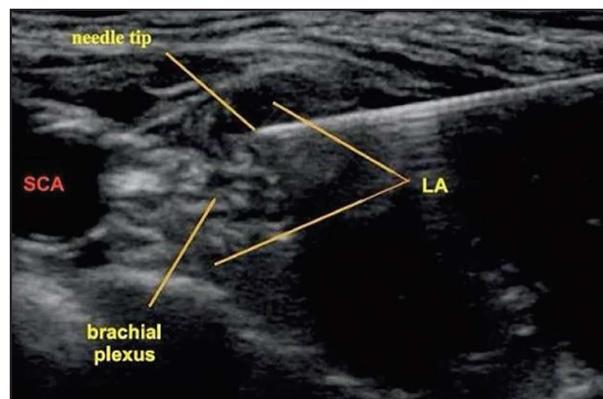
Ultrasonic image of the block
